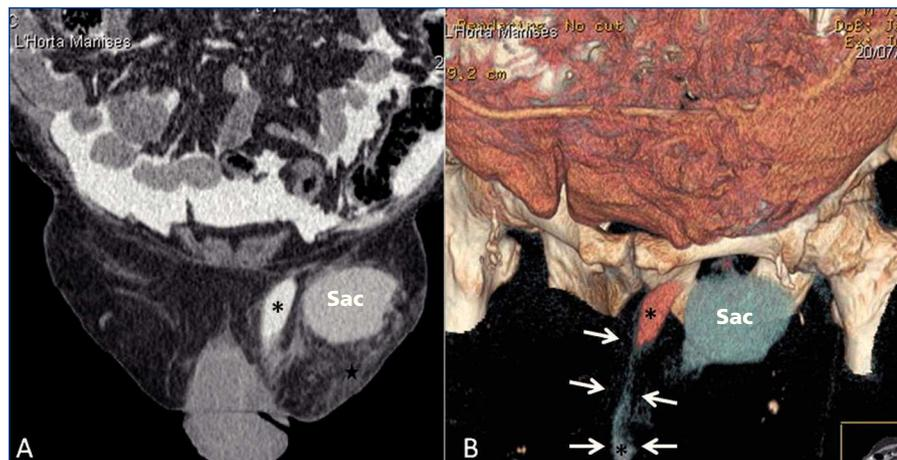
CT peritoneography.
